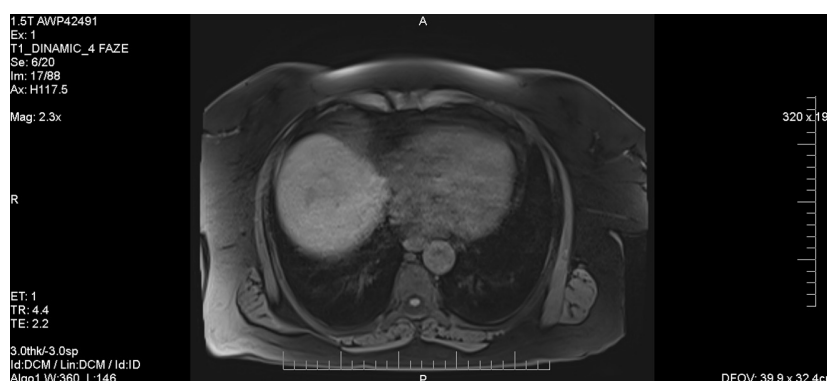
Abdominal MRI showing liver mass in the hepatic dome. MRI: magnetic resonance imaging
